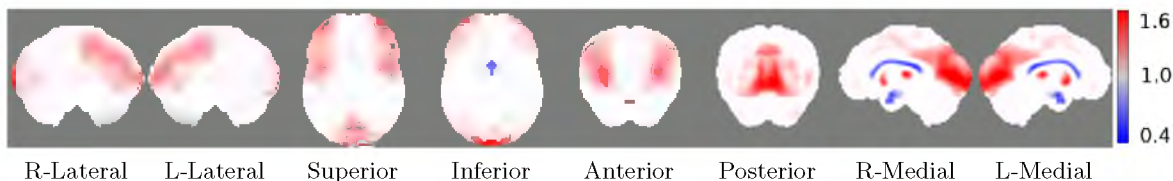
FDG-PET: Discriminating regions obtained from classifier weights for prediction of MCI conversion to AD in 3D-SSP Z-score space.
